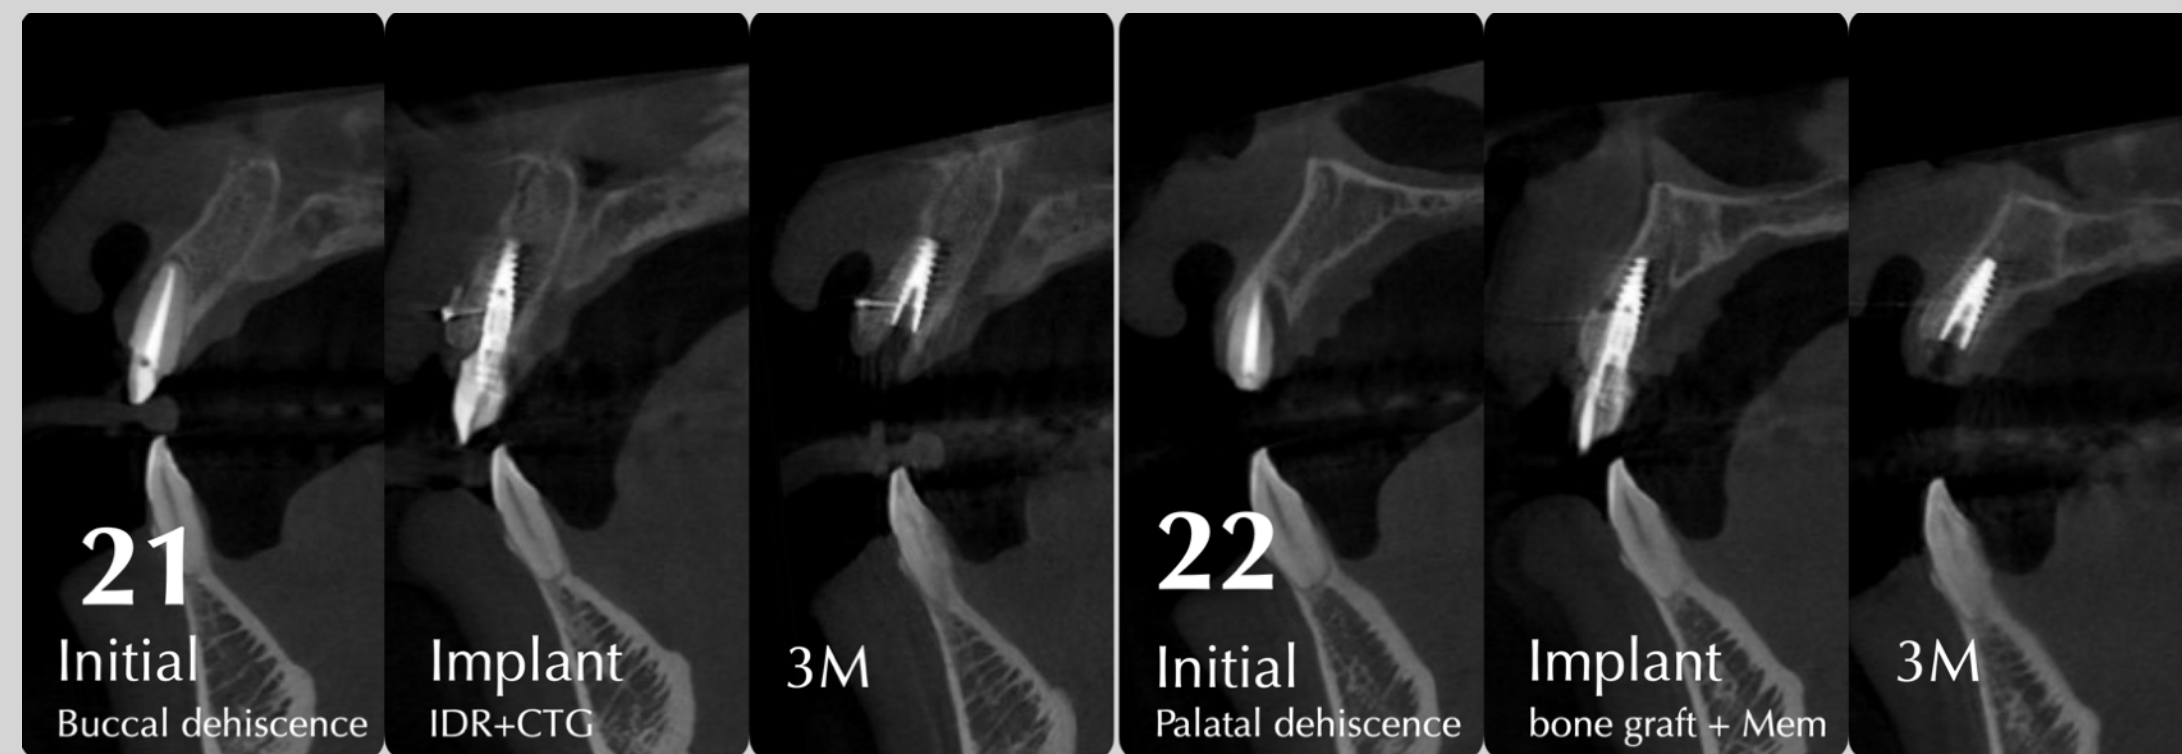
CBCT images of #21 and #22 at baseline, immediate postoperative, and 3 months.
